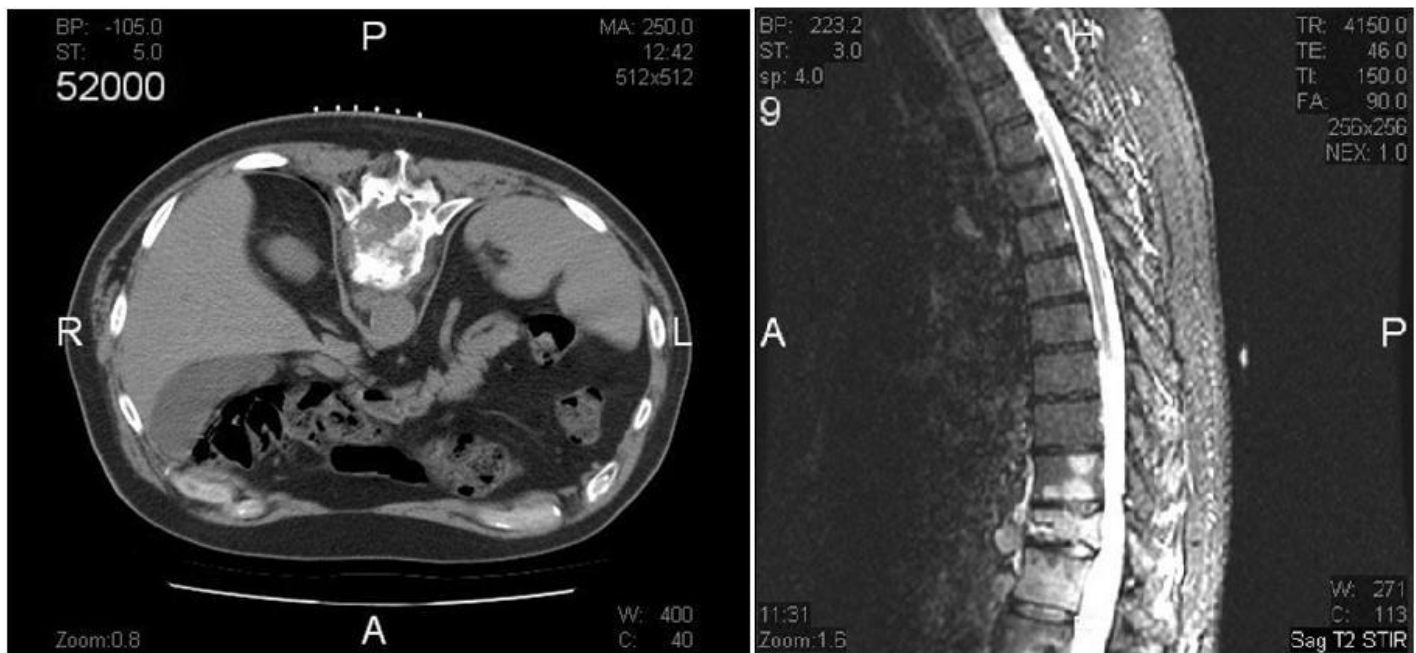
Magnetic resonance image (MRI).
